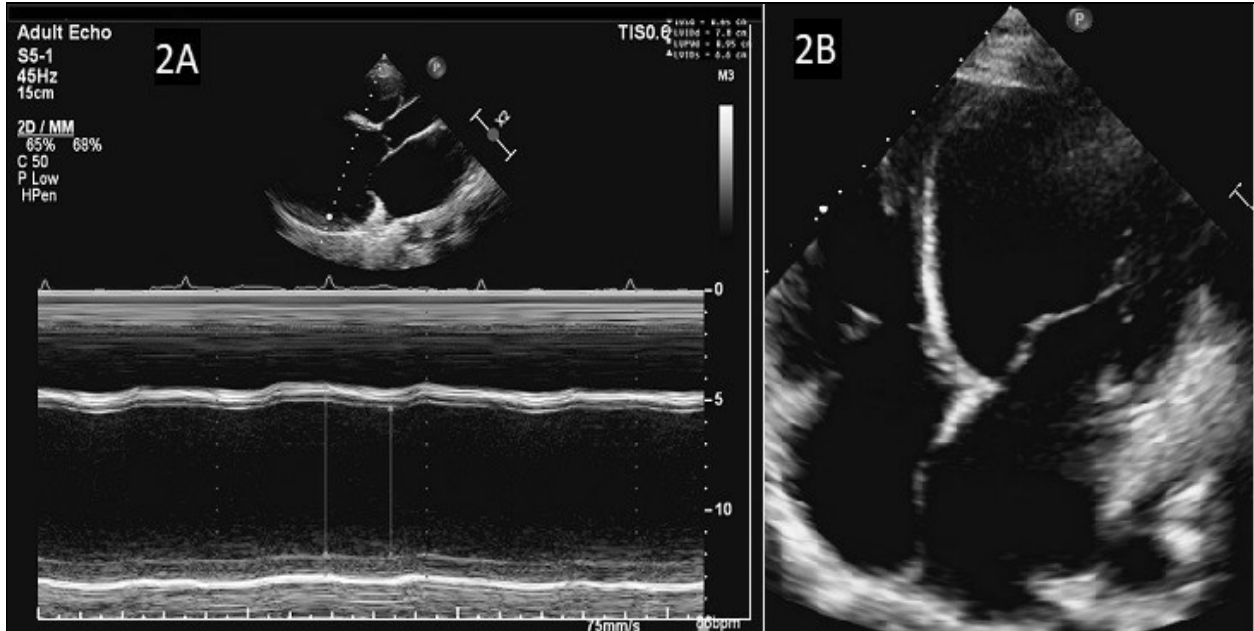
Echo images. 2A: M-Mode of dilated Left ventricle and left atrium and showing severe left ventricle systolic dysfunction, 2B: dilated left ventricle and left atrium in apical 4 chamber view.
